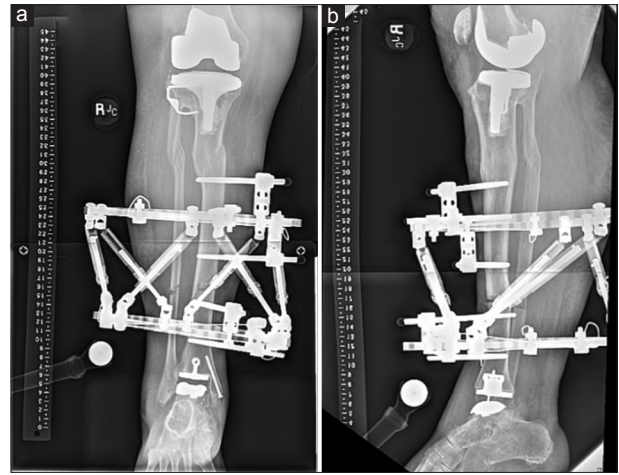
(a) Anteroposterior and (b) lateral radiographs 2 weeks following Taylor Spatial Frame placement. The proximal ring was 91.4 mm from the distal edge of the knee prosthesis; proximal pin 52.2 mm. Distal ring was 22.3 mm from proximal edge of ankle prosthesis; distal pin 15 mm
